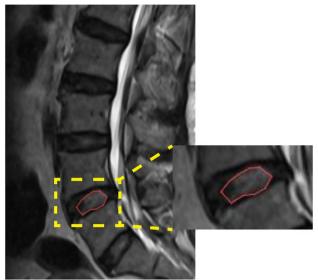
The area of nucleus pulposus (NP) on magnetic resonance imaging (MRI)
